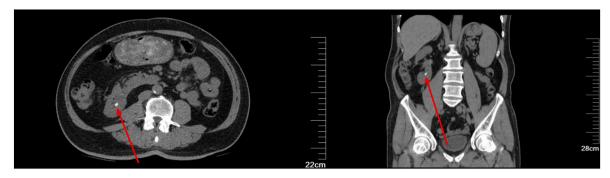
Axial and coronal sections of non-contrast CT scan only showing a 7 mm stone in the right lower calyx.
